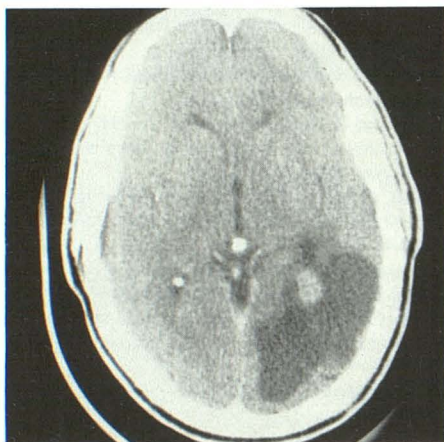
Postcontrast CT scan shows a large cystic mass with a central, enhancing nodule in left occipital region adjacent to glomus of choroid plexus.
